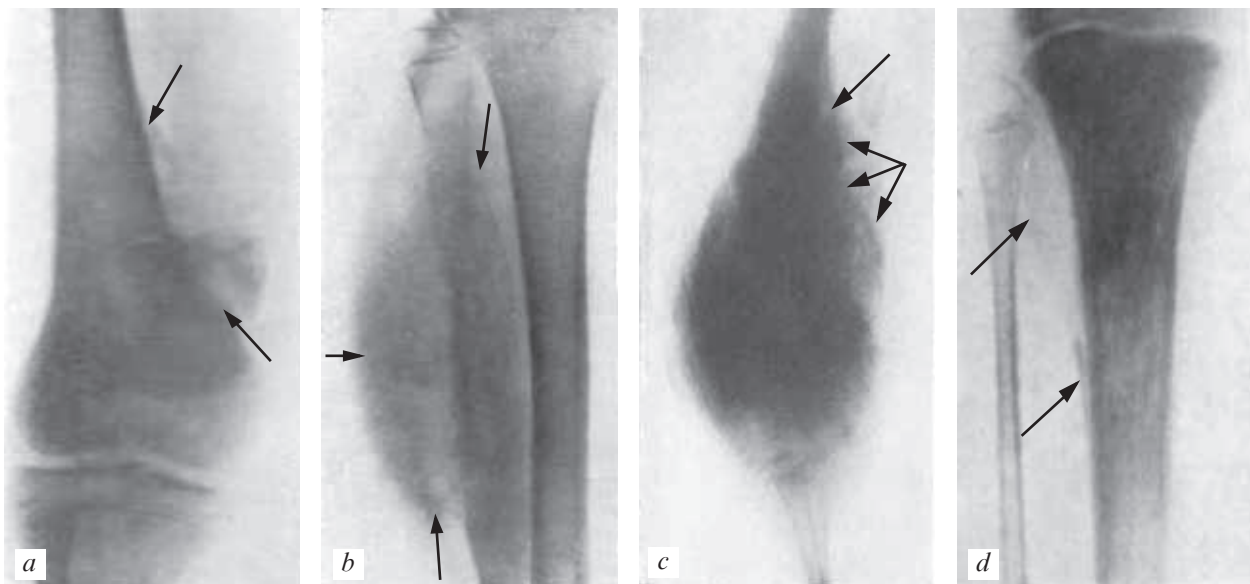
Radiographic signs of osteosarcoma: *a* — osteogenic sarcoma of the femur, *b* — a tumor of the fibula, *c* — osteogenic sarcoma of the humerus, *d* — the defeat of the tibia
